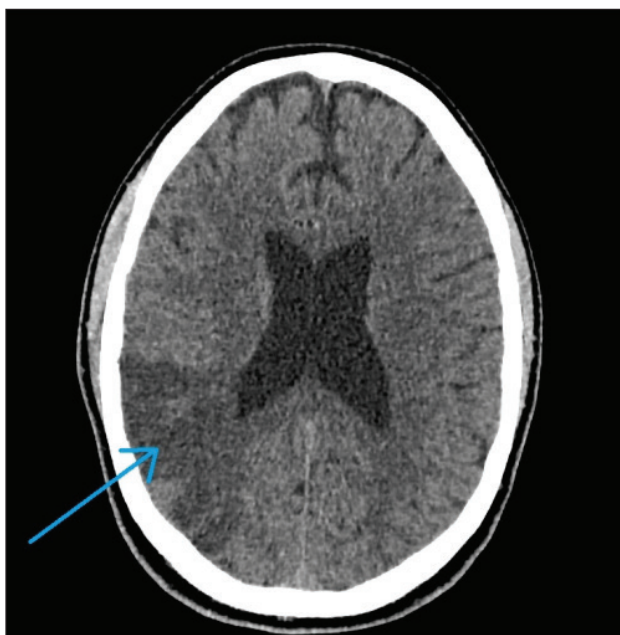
CT of the head: Right temporal gyrus acute ischaemic stroke with mild mass effect, no intracranial haemorrhage. 194 × 196 mm (96 × 96 DPI).
